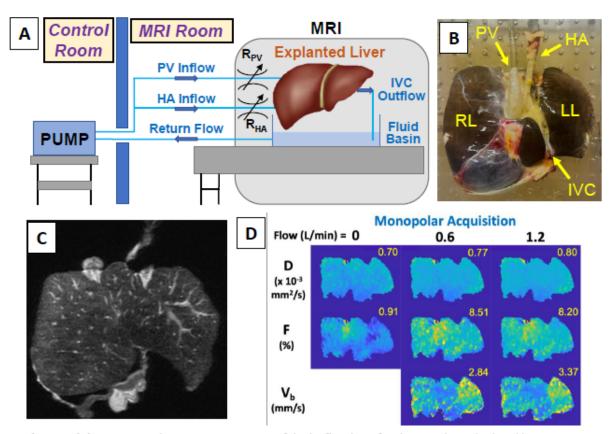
(A) Experimental MRI setup consisting of dual inflow lines for the portal vein (PV) and hepatic artery (HA) Each inflow line included a resistive valve (R) to constrain the inflow ratio. The inferior vena cava (IVC) outflow was collected in a fluid basin. (B) Image of explanted liver and flow connections. (C) T2-weighted MRI image of explanted liver. (D) Representative explanted liver IVIM parameter maps of the diffusion coefficient (D), perfusion signal fraction (F), blood velocity standard deviation (V_b). Estimates for each parameter are given in the upper right corner of each map
